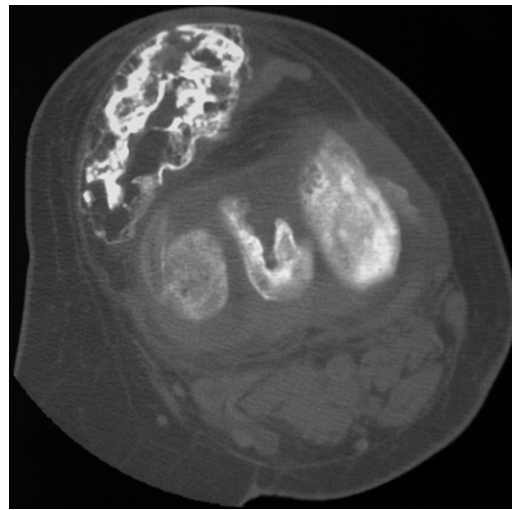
Para-articular osteochondroma in a middle-aged woman. Axial CT image through the left knee shows a large partially ossified mass in the medial infrapatellar fat pad displacing the patellar tendon anteriorly. The underlying bone appears normal. The mass was surgically excised. (Courtesy of Dexter Witte, MD, Baptist Hospital, Memphis, Tenn.)
